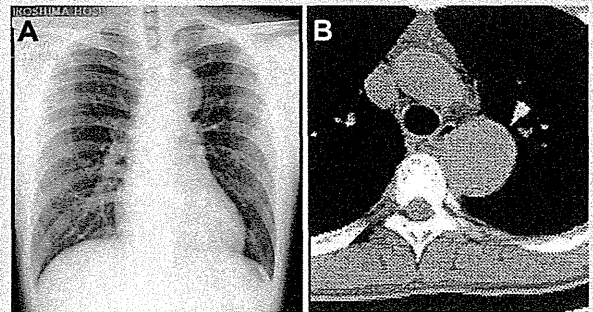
Imaging studies of Patient 2 at 30 years. A: Chest radiograph showing the projection of aortic arch. B: Chest 3D-CT demonstrating fusiform dilation of the descending thoracic aorta.
